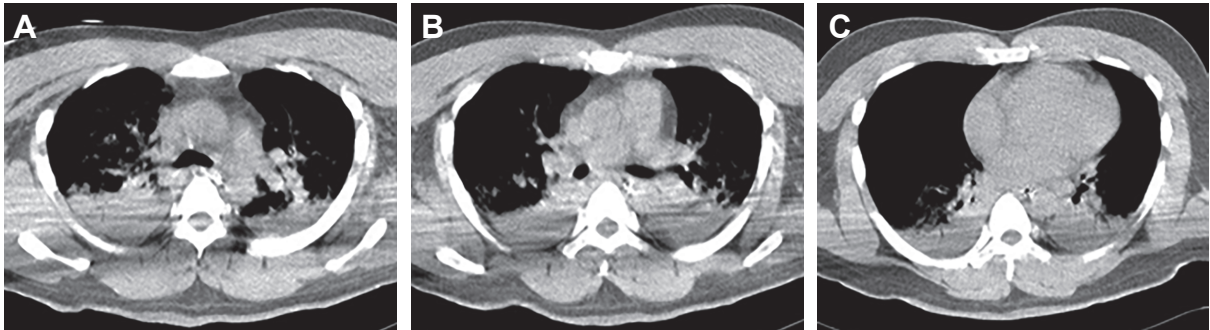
The axial view of chest CT at ER showed relatively symmetric consolidation at dependent zones of both lungs. However, the consolidation of right upper lobe seemed larger than that of left upper lobe. (A) Chest CT axial view at primary bronchus level. (B) Chest CT axial view at inferior lobar bronchus level. (C) Chest CT axial view at segmental branches level of inferior lobar bronchus.
